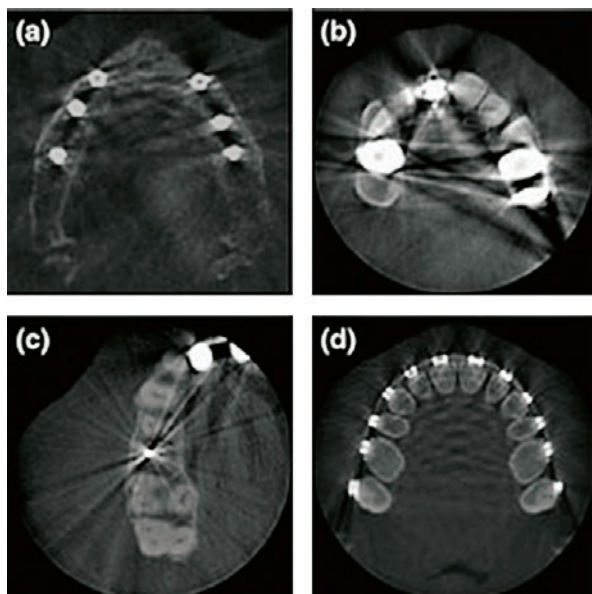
Metal artifacts in CBCT footage
